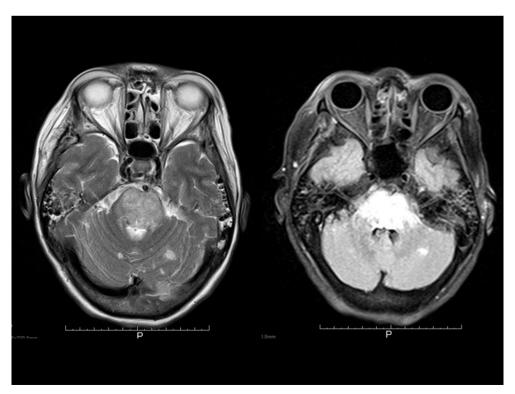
Magnetic resonance imaging of brain shows severe ischemia in the brainstem. There is an image of a thrombus in the basilar artery.
